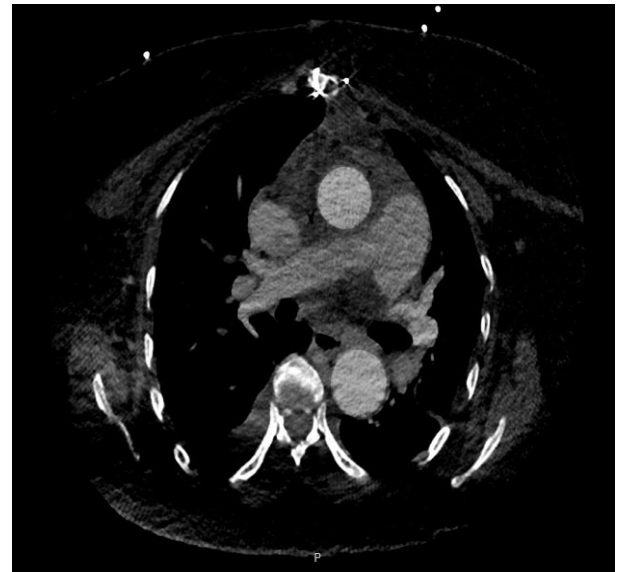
Postoperative thoracic computed tomographic scan, transverse view, (with contrast agent), showing the good result of the procedure of the frozen elephant trunk.
